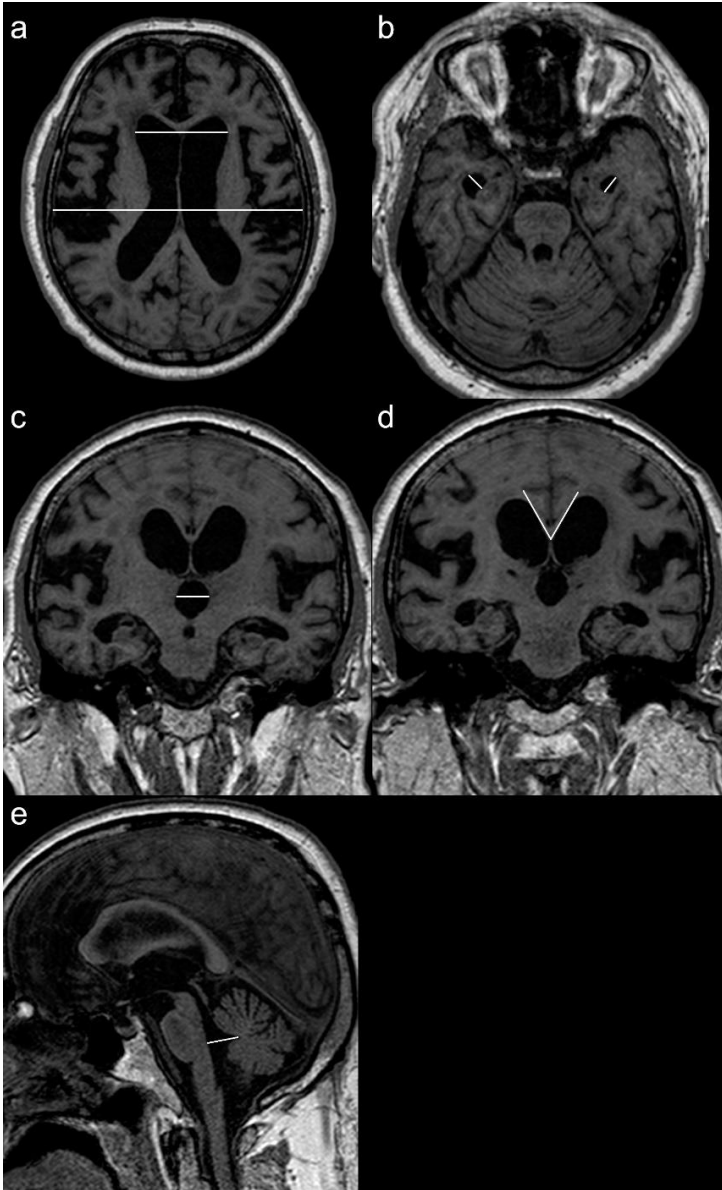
Evans' index measured as the ratio between the maximum width of the frontal horns of the ventricles divided by the maximum inner skull diameter (a), and maximum width of the temporal horns (b) on transaxial images. Maximum width of the 3rd ventricle (c) and CC-angle (d) measured on coronal images. Maximum anteroposterior diameter of the 4th ventricle measured on a sagittal image (e). All images are T1-weighted.
